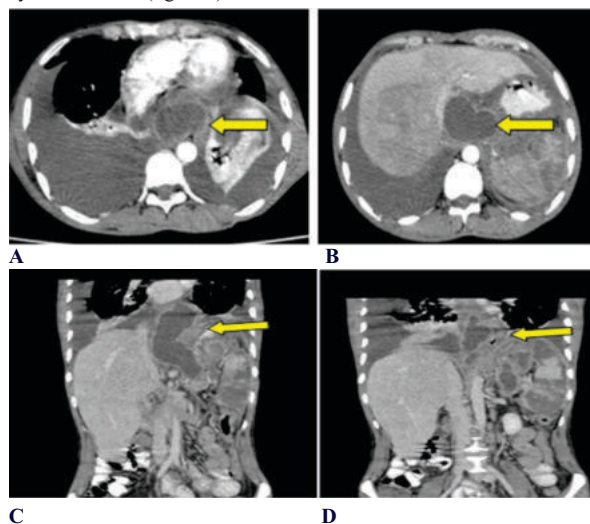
(A, B, C and D) Axial and coronal contrast CT shows rim enhancing cystic lesion in the posterior mediastinum which is contiguous with cystic abnormality in the distal body and tail of the pancreas representing Pseudocyst of pancreas.
